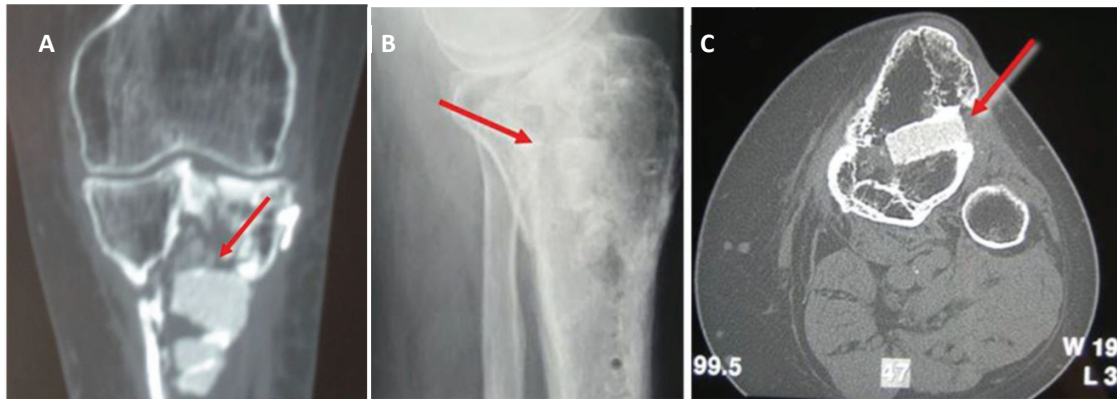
HA-TCP bone substitute in proximal tibia traumatic bone loss. X-rays (A and B) and CT scan (C) at 3-year follow-up in the proximal tibia without resorption of bone substitute. The red arrow is pointing out the implanted scaffold (adapted from Campana et al. 2014).
